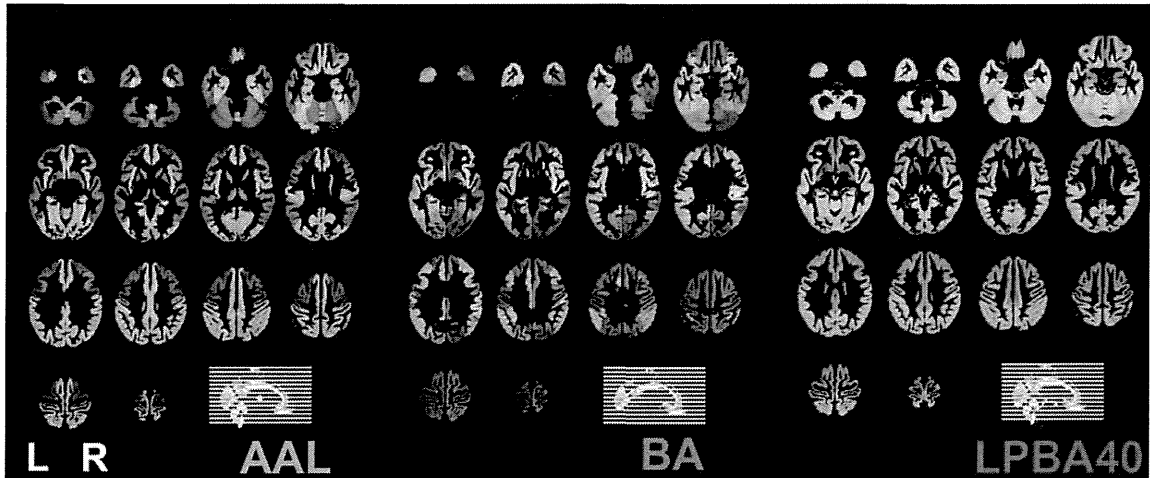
Three brain atlases used for feature extraction, overlaid to representative structural MR images. AAL, Automated Anatomical Labeling; BA, Brodmann's areas; LPBA40, LONI Probabilistic Brain Atlas.
